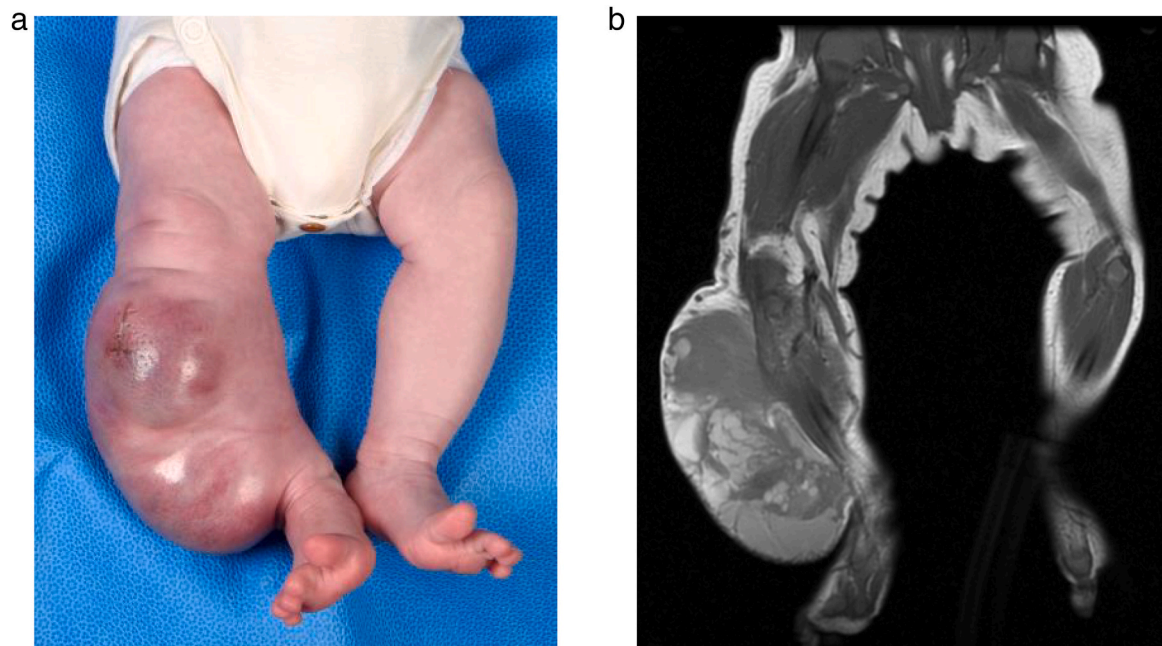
Case 1: a. Clinical picture of the tumor at the right lower leg at presentation. b. MRI imaging of the right lower leg in coronal plane: T1 FSE (Fast spin echo) sequence shows the heterogeneous mass with extensive hemorrhagic components with high T1 signal.
